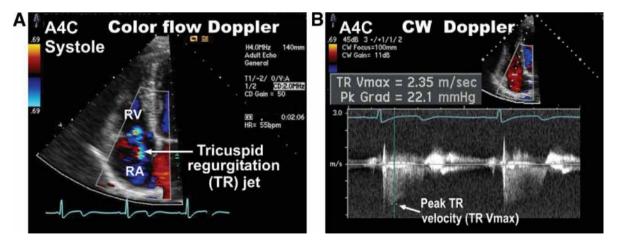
Apical four-chamber view (A4C). (A, see companion DVD.)
